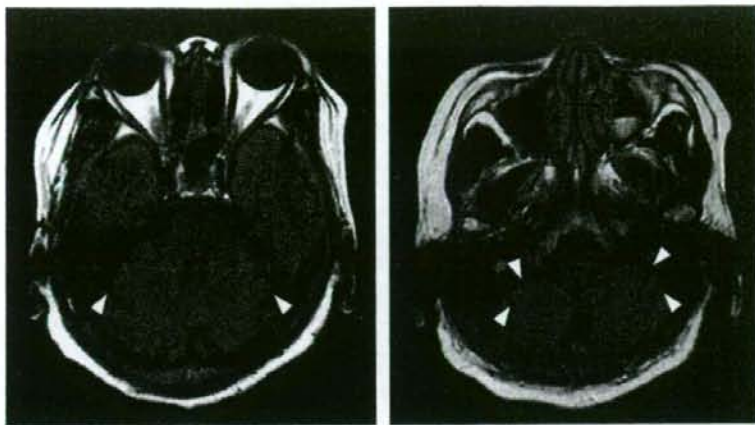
Brain MRI (1.5T FLAIR) of our patient. Symmetric dilation of cerebellar fissure (arrow heads), indicating mild cerebellar atrophy.
